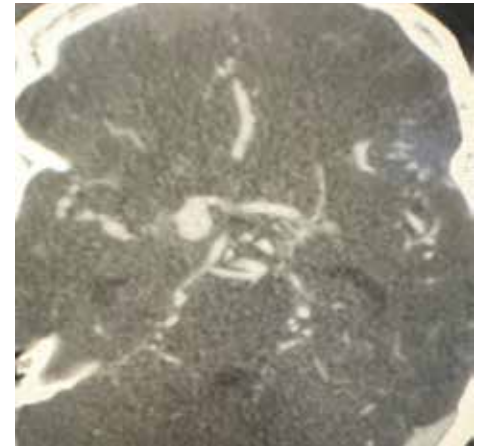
Axial CTA demonstrating wide neck right posterior communicating artery aneurysm
